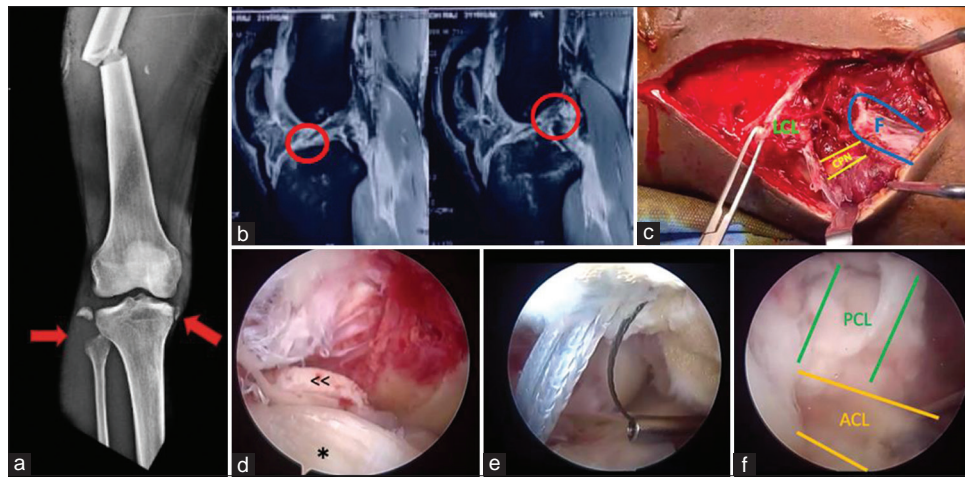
Case 1 (a) X-ray showing LCL avulsion fracture (red arrow over fibular head) with reverse Segond's fracture (red arrow over medial proximal tibia). (b) MRI showing tibial avulsion of ACL (left MRI image) and femoral avulsion of PCL (right MRI image) indicated by red circles. (c) Clinical image showing LCL avulsion fracture. (d) Arthroscopic image showing torn ACL and PCL. (e) Shuttle of sutures through the bony tunnels. (f) Repaired ACL and PCL. *-ACL, <<-PCL, F-Fibula head, CPN: Common peroneal nerve, LCL: Lateral collateral ligament, ACL: Anterior cruciate ligament, PCL: Posterior cruciate ligament, MRI: Magnetic resonance imaging
